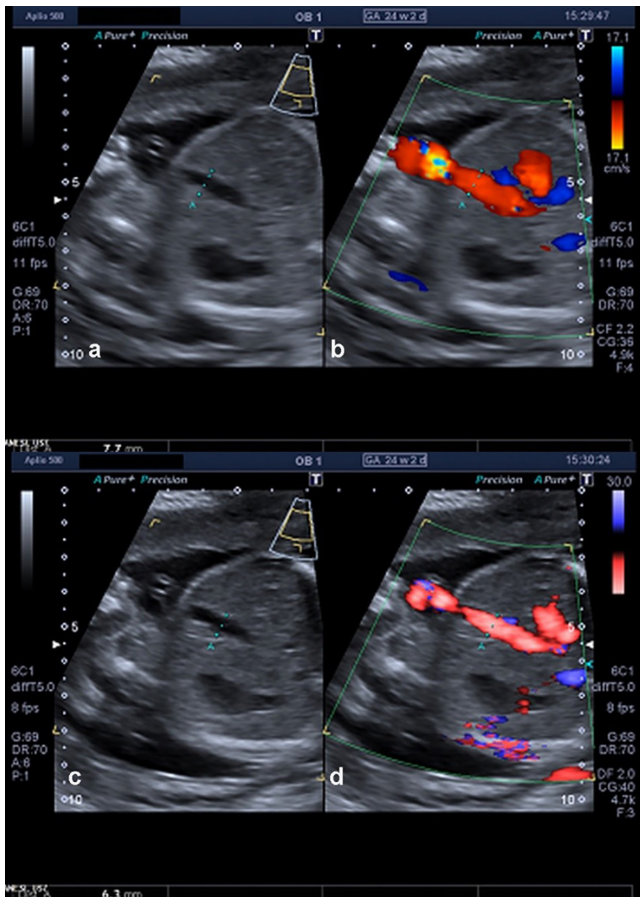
(a) Twin-view with CCD technique image of vessel diameter measurement from B mode side. (b) Twin-view with CCD technique image of vessel diameter measurement from CCD Doppler side. (c) Twin-view with ADF technique image of vessel diameter measurement from B mode side. (d) Twin-view with ADF technique image of vessel diameter measurement from ADF Doppler side.
